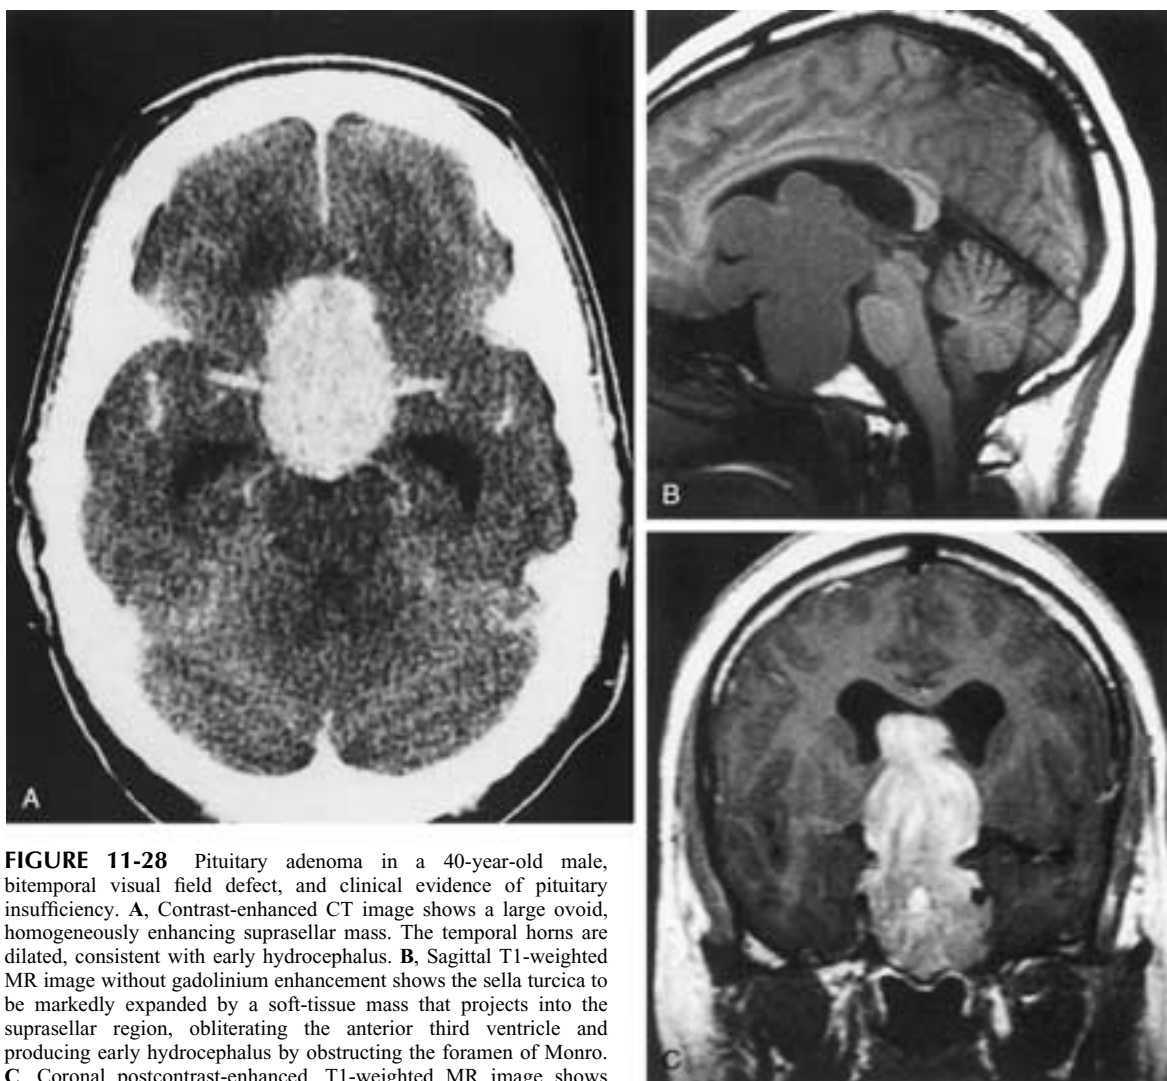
Pituitary adenoma in a 40-year-old male, bitemporal visual field defect, and clinical evidence of pituitary insufficiency. A, Contrast-enhanced CT image shows a large ovoid, homogeneously enhancing suprasellar mass. The temporal horns are dilated, consistent with early hydrocephalus. B, Sagittal T1-weighted MR image without gadolinium enhancement shows the sella turcica to be markedly expanded by a soft-tissue mass that projects into the suprasellar region, obliterating the anterior third ventricle and producing early hydrocephalus by obstructing the foramen of Monro. C, Coronal postcontrast-enhanced, T1-weighted MR image shows enhancement throughout the solid tumor.
